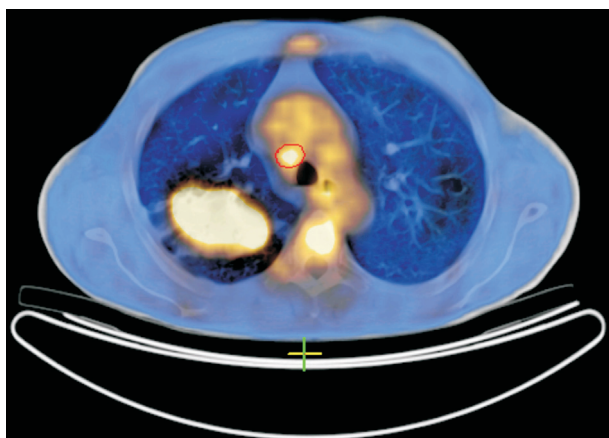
Fusion of FDG-PET and CT images shows mediastinal lymph node metastases undiscerned in computed tomography
